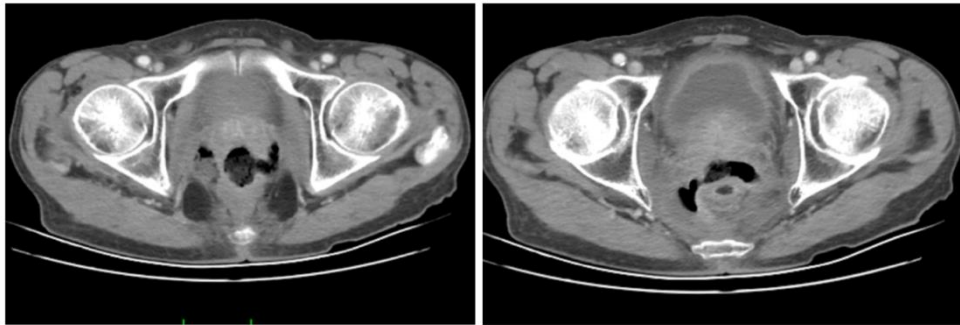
CT imaging showing anastomotic dehiscence
